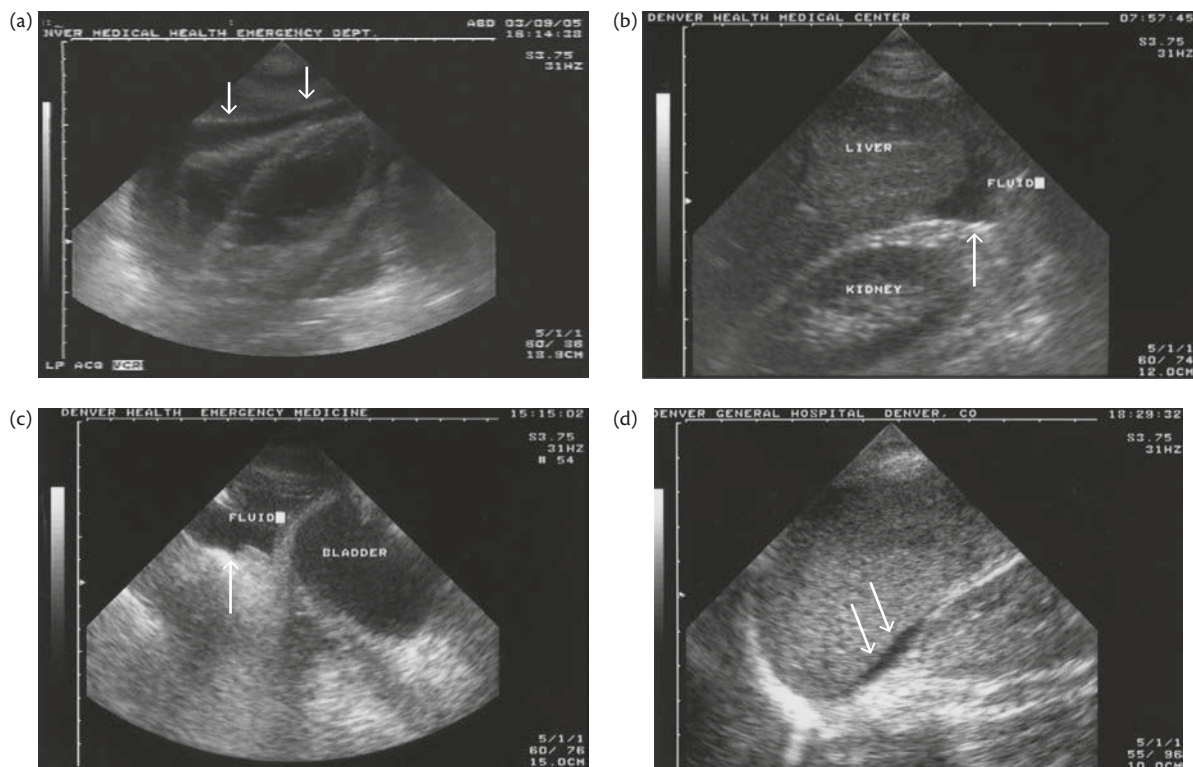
Focused Abdominal Sonography for Trauma (FAST) examination can identify blood in (a) the pericardium, (b) right upper quadrant, (c) pelvic space, and (d) left upper quadrant.
